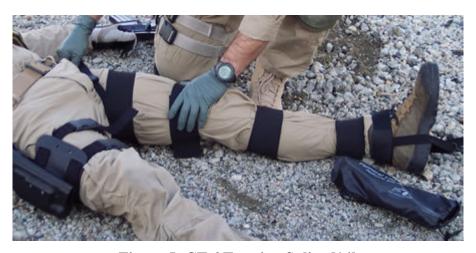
CT-6 Traction Splint [14]
